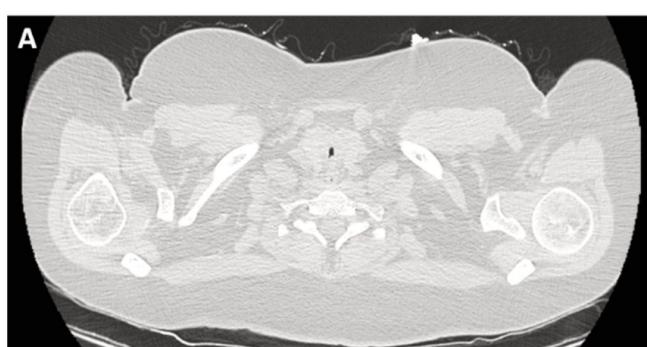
Subglottic stenosis is evidenced in the computed tomography scan performed in 2022 (A) and after treatment in 2024 (B).
